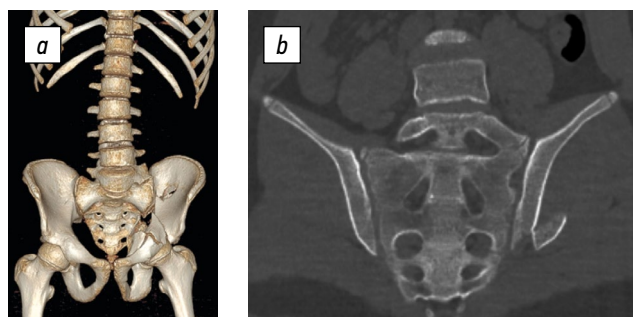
Three-dimensional reconstruction (a) and CT scan (b) of the lower thoracic and lumbar spine, pelvic bones, and hip joints of a 16-year-old female patient. Subtype IIIb injury of the left side of the pelvis (acetabular and iliac wing fractures). Transitional lumbosacral vertebra, subtype IIa.
